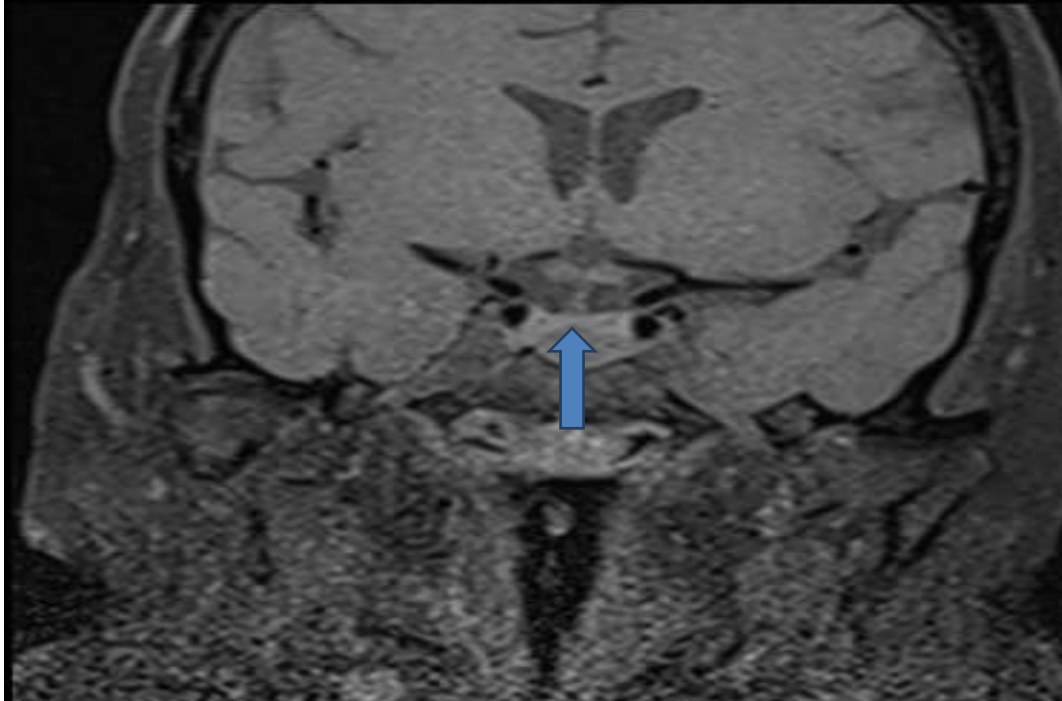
Preoperative coronal hypothalamic-pituitary MRI showing a pituitary macroadenoma.
